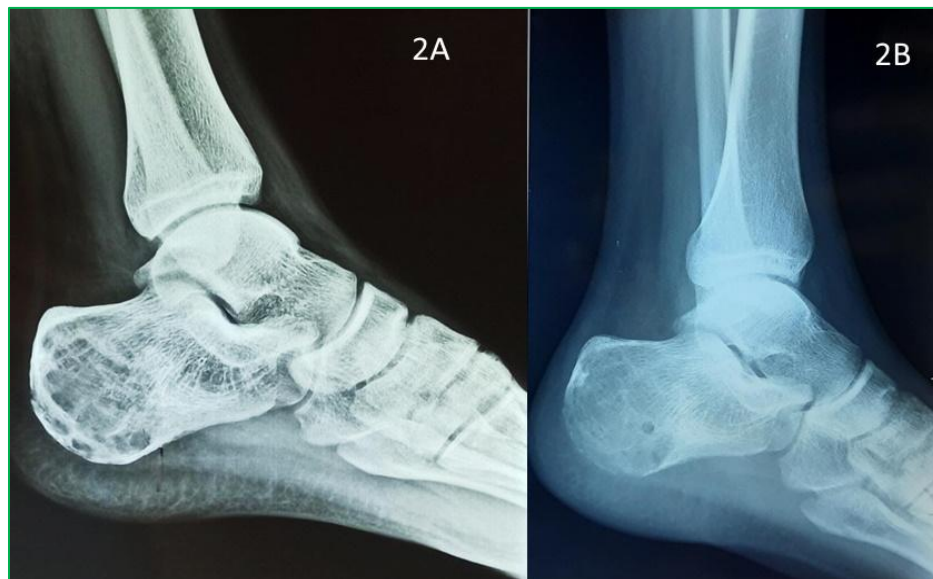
X-ray on left foot before and after injection
